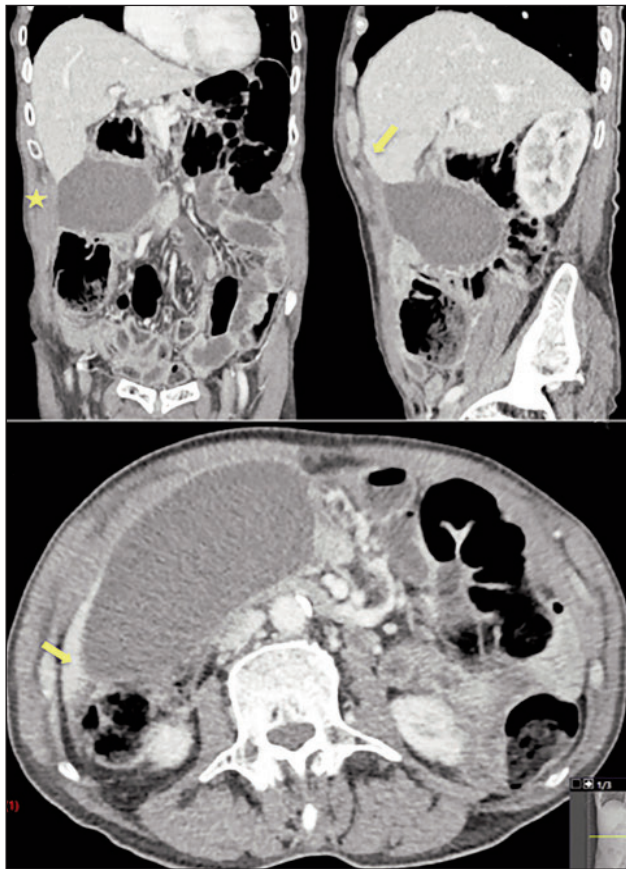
CT images: (a) distended lumen of the gallbladder (star); (b, c): the distended lumen of the gallbladder transitions to the narrow fulcrum points at its neck (yellow arrow)
